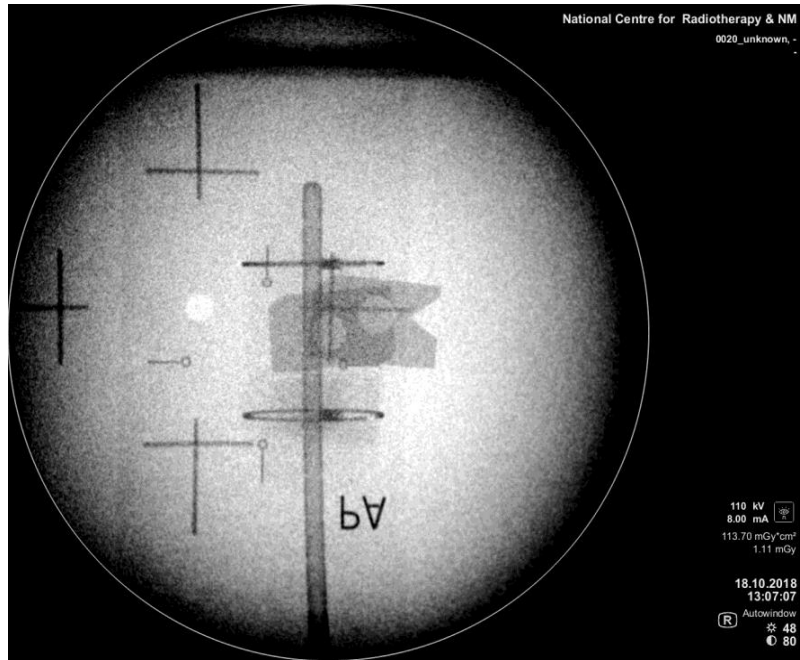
An Anterior – Posterior (AP) Radiograph of the Applicator
